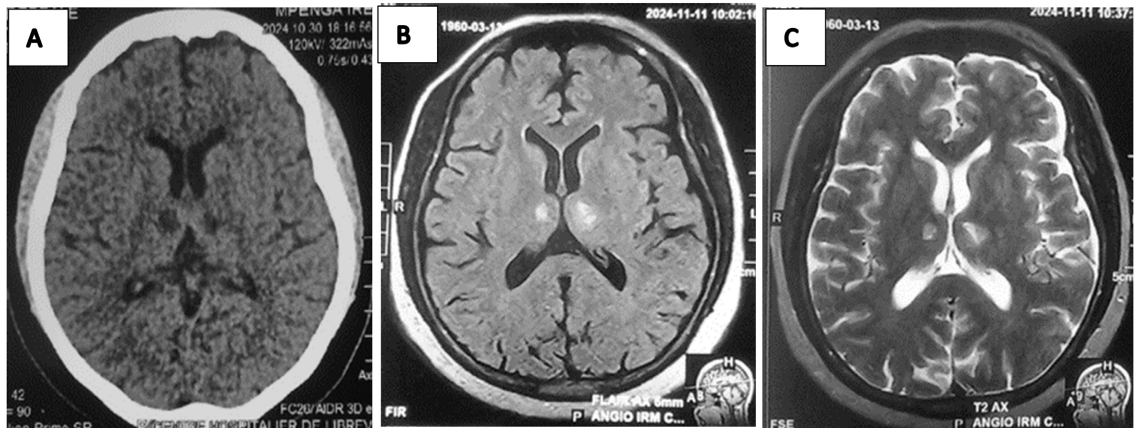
Day-5 brain CT showing paramedian bithalamic hypodensities (A). Axial brain MRI demonstrates bilateral thalamic lesions hyperintense on FLAIR (B) and T2 (C), consistent with an established bithalamic infarction.
